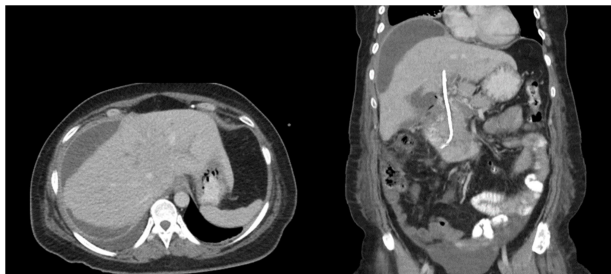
CT scan axial and coronal slice showing hepatic subcapsular hematoma.
